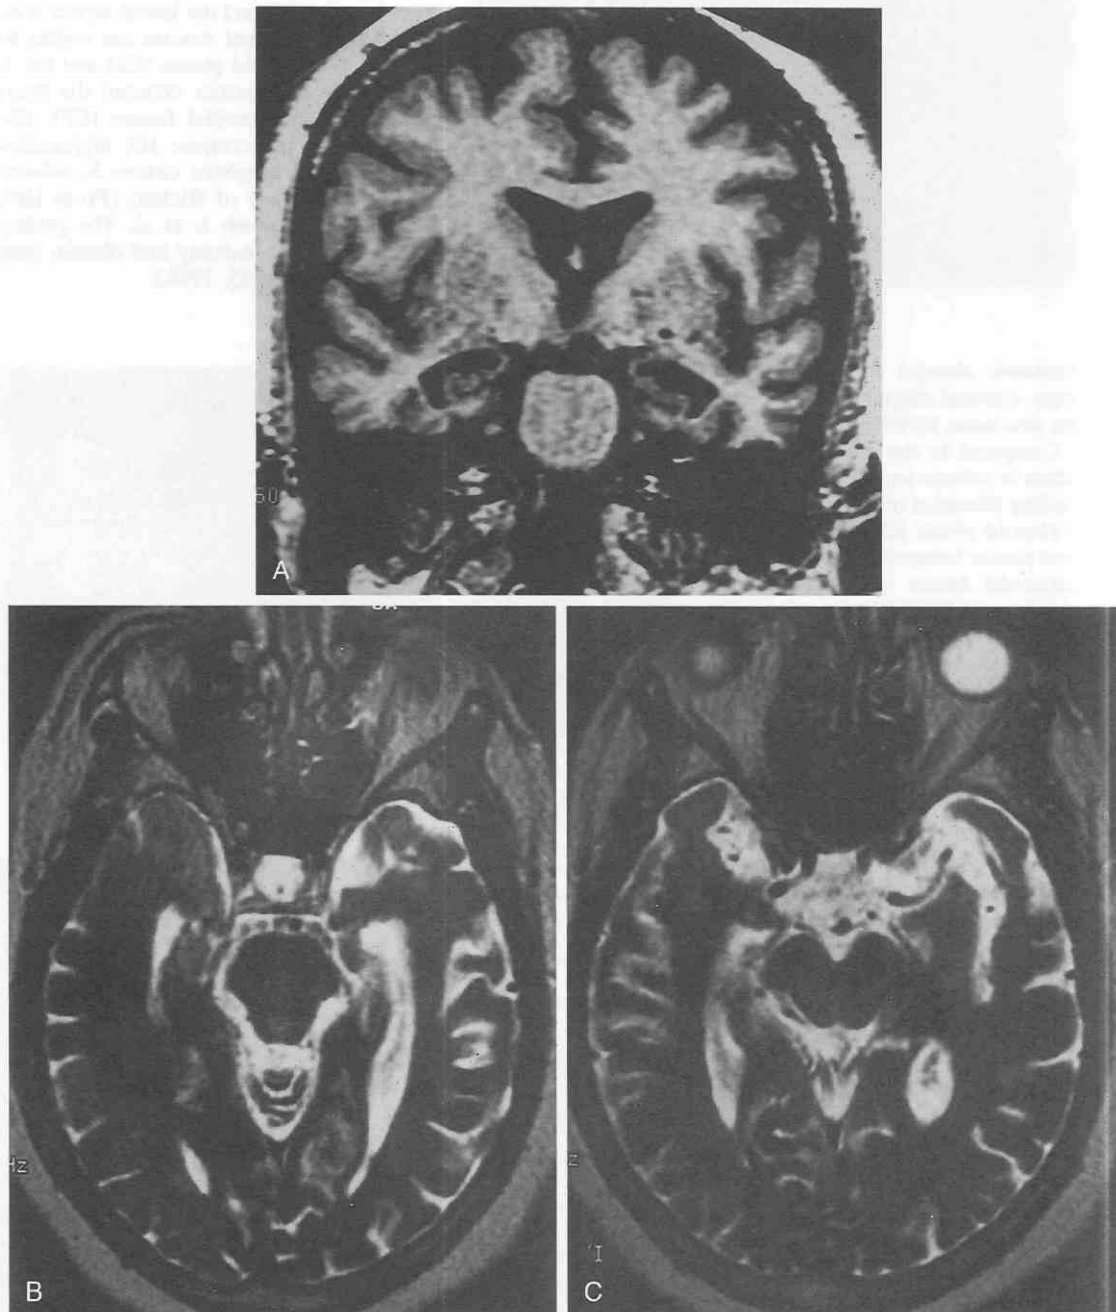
Presumed Alzheimer's disease in a 60-year-old woman. *A*, Coronal T1-weighted MR image demonstrates severe atrophy of the hippocampus and dilatation of the perihippocampal fissures. *B* and *C*, Reverse-angle axial T2-weighted images in the same patient. These images demonstrate the importance of evaluating for prominence of the perihippocampal fissures and hippocampal atrophy in the correct plane. *B* is inferior to *C*. In *B*, the left medial temporal lobe demonstrates prominent perihippocampal fissures (the area of increased signal intensity between the temporal horn and the pons). The right medial temporal lobe on image *B* fails to demonstrate this area of increased signal intensity. This is because the patient is slightly tilted and one is actually scanning through the area of the parahippocampal gyrus (see Fig. 10-1), not the atrophic hippocampus. An analogous situation exists in *C*. The dilated perihippocampal fissures are seen on the right. The scanning plane on the left side is directed superior to the perihippocampal fissures and therefore does not demonstrate the area of increased signal intensity associated with dilated perihippocampal fissures. (From Holodny AI, George AE, Golomb J, et al: The perihippocampal fissures: Normal anatomy and disease states. Radiographics 18: 653-665, 1998.)
